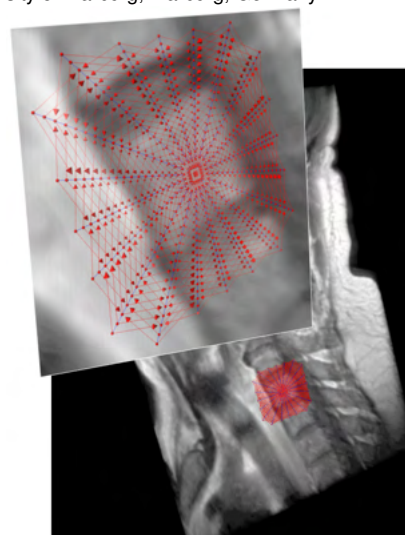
Graph within a MRI dataset.
